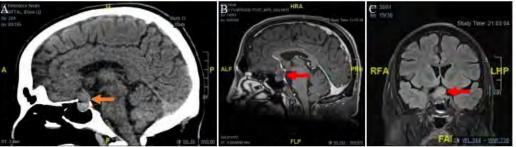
Hyperattenuating 2.0 cm x 2.8 cm x 1.5 cm mass (orange arrow) at the sella turcica on unenhanced CT (A); 1.9 cm x 3.2 cm x 2.4 cm heterogeneous mass (red arrow) on T1 (B); and T2-weighted imaging with flattening of the optic chiasm, remodeling/dehiscence of the floor of the sella and extending into the right cavernous sinus with at least partial encasement of the ICA (C)
